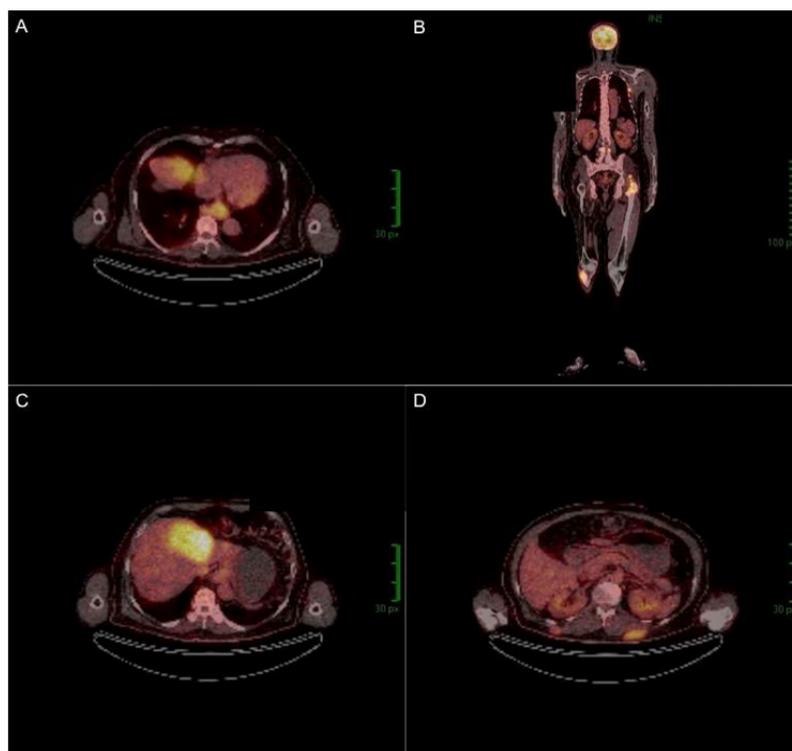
PET-CT scan showed a metabolically active tumor in the distal esophagus (A) and metastatic involvement of bone, liver, pancreas, left kidney, mesentery, abdominal, mediastinal and left axillary lymph nodes, choroid of the left eye and lumbar soft tissues (B,C,D).
